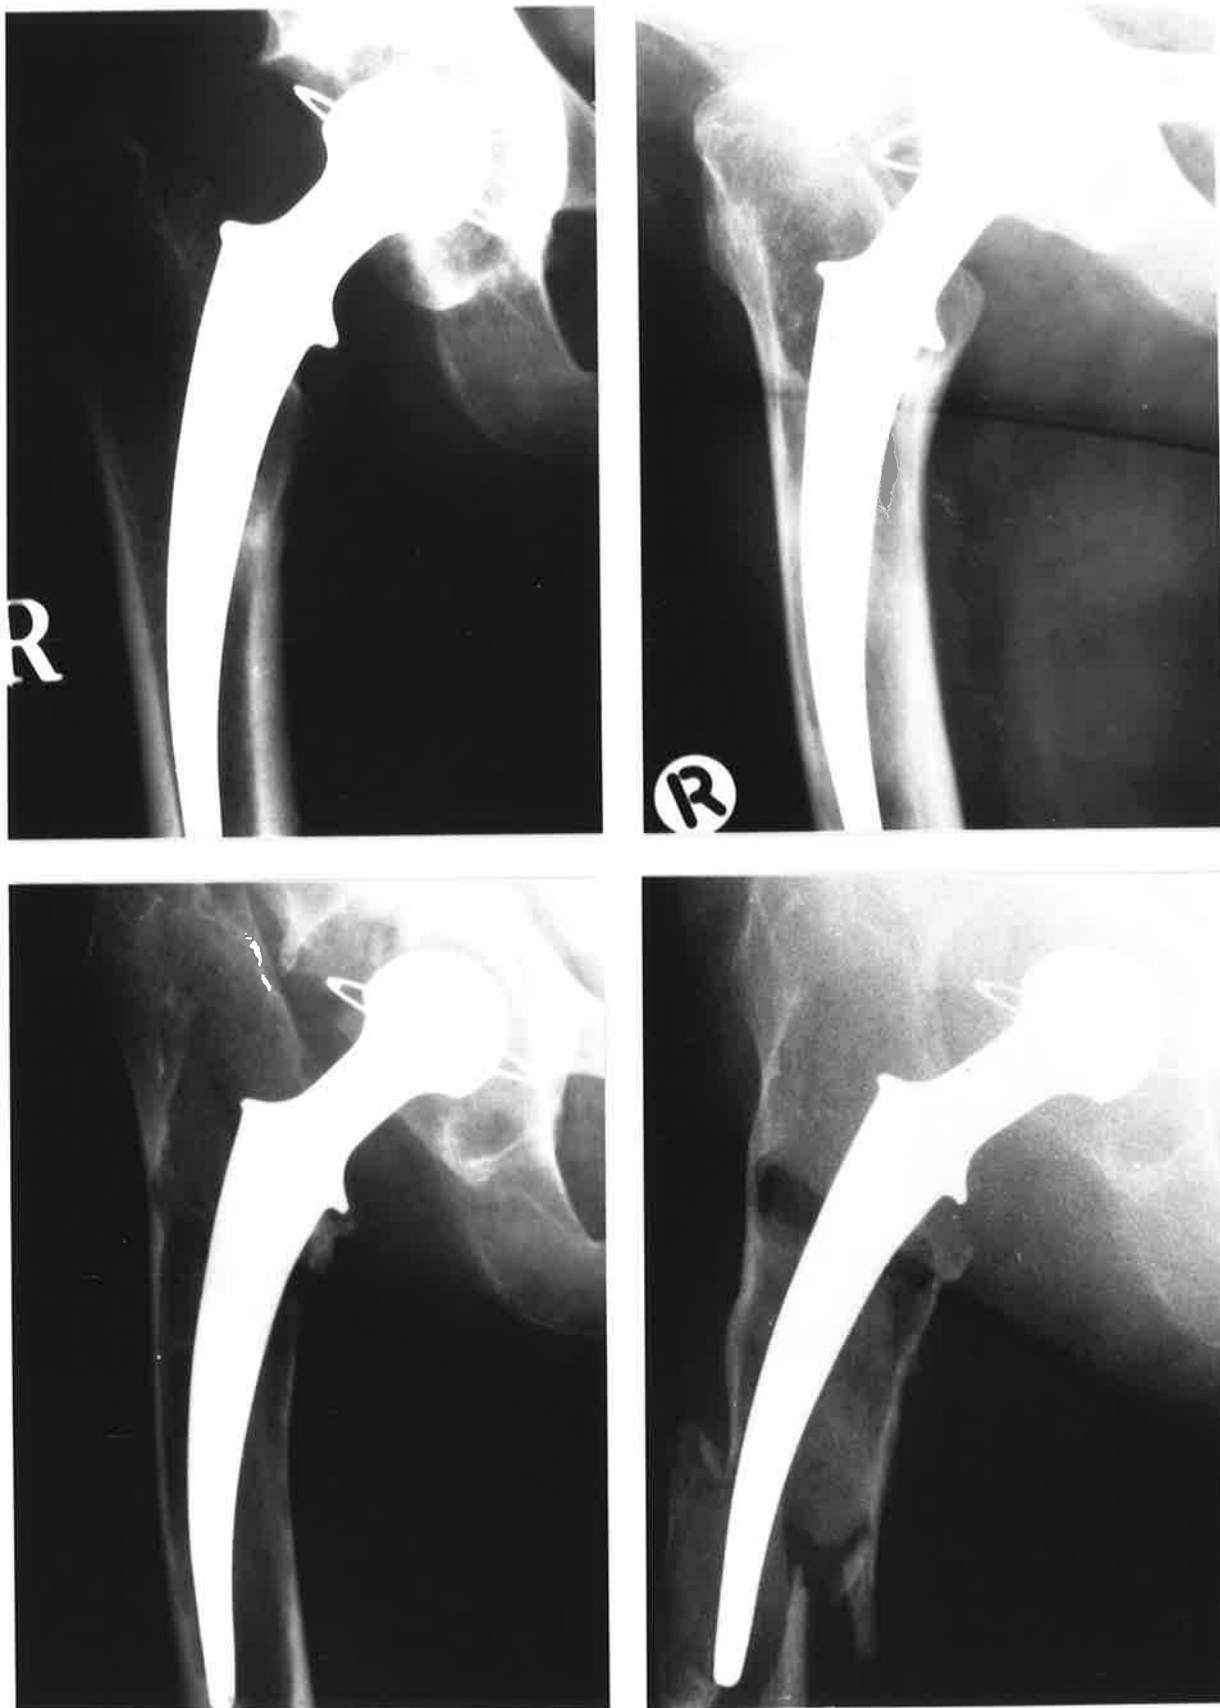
Serial radiographs of a cemented Muller metal on polyethylene arthroplasty at approximately two yearly intervals following insertion. The cement is radio-lucent. Progressive bone loss is seen in association with loosening of the prosthesis, culminating in fracture of the femoral shaft. The scalloped appearance of the bone is typical of bone resorption due to the response to particulate material.
